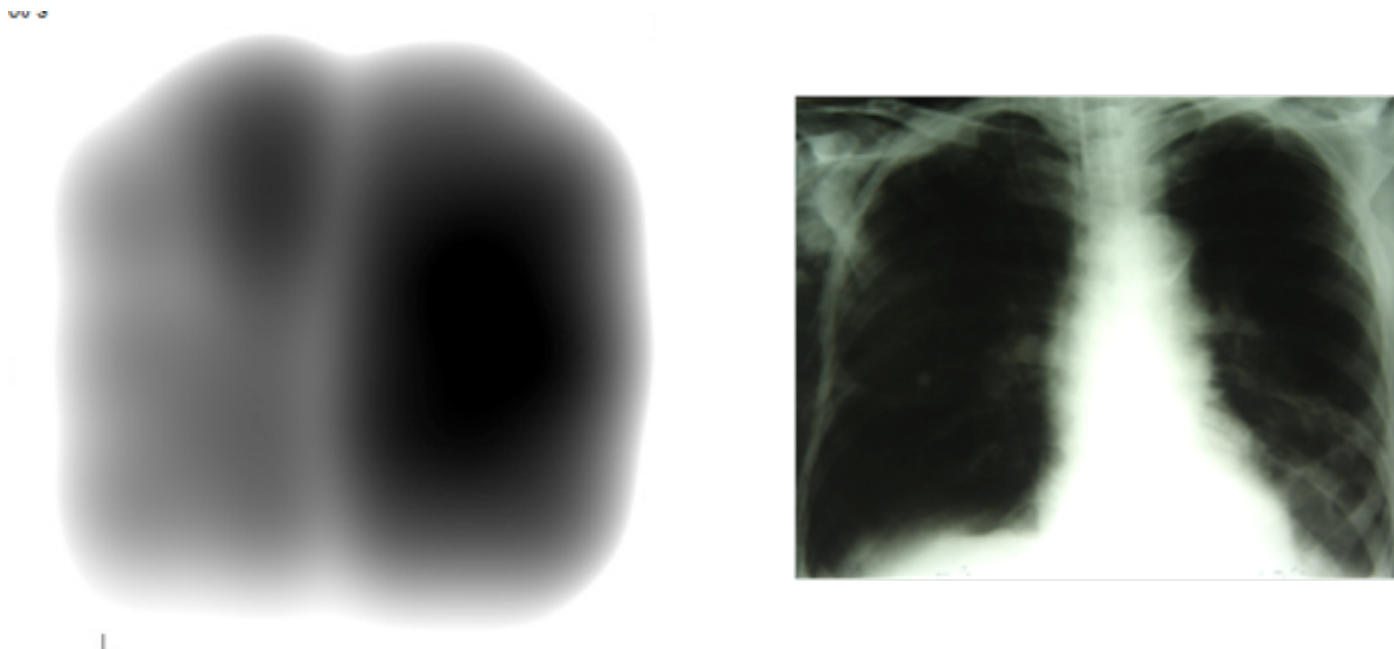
Comparison of findings in VRI and lung x-ray - right sided pneumothorax
